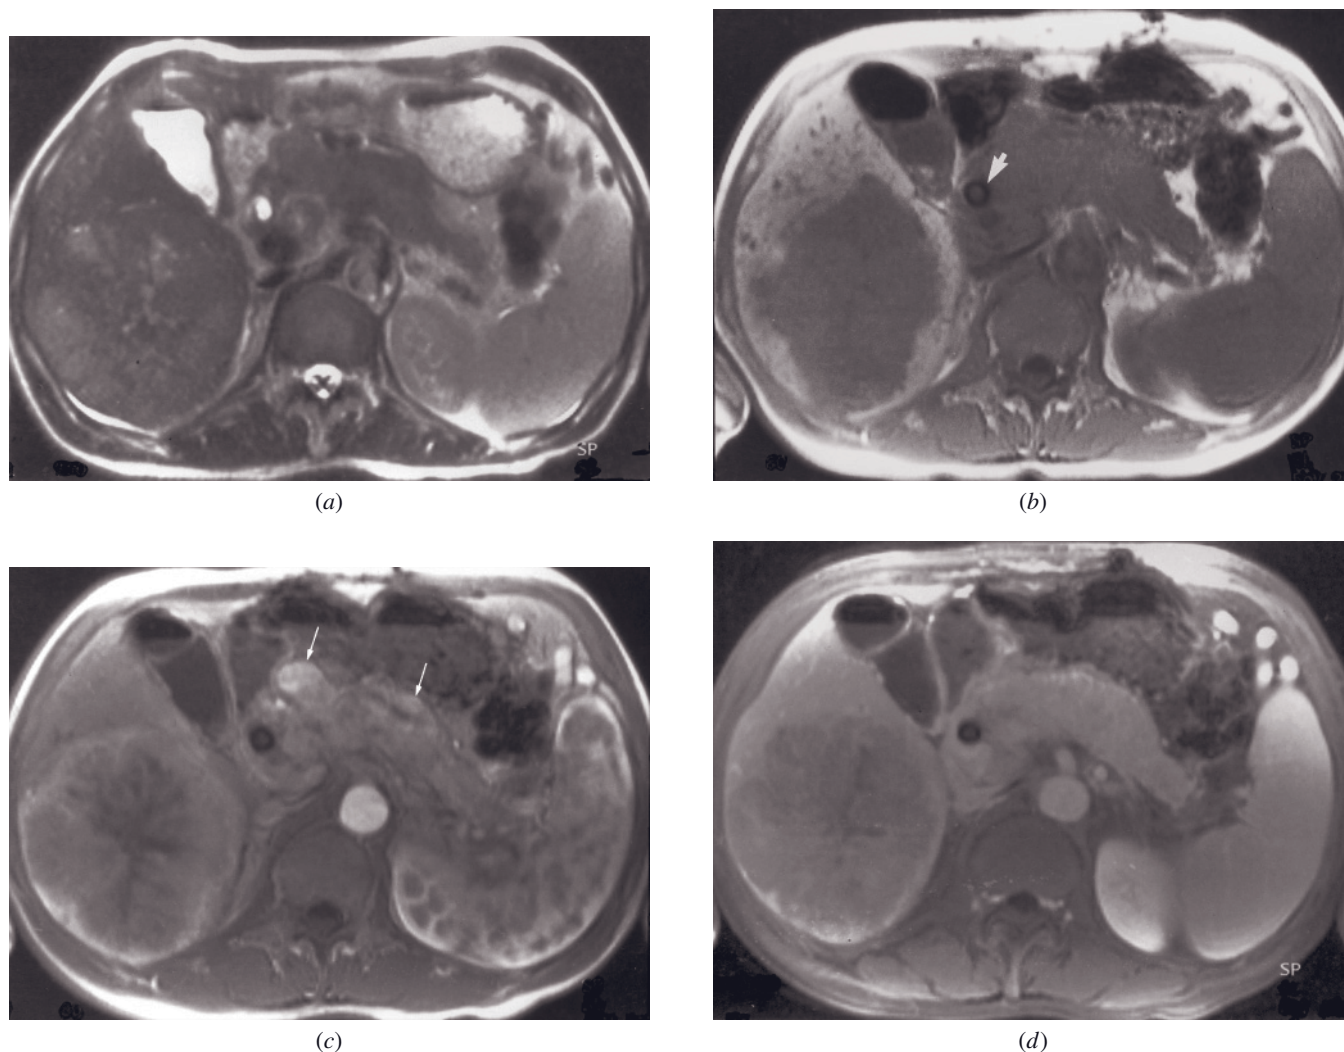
Carcinoid tumor with liver metastases. T2-weighted echo-train spin-echo (a), T1-weighted SGE (b), immediate postgadolinium T1-weighted SGE (c), and 90-s postgadolinium fat-suppressed SGE (d) images in a patient with a carcinoid tumor with diffuse involvement of the pancreas and hypervascular liver metastasis. The pancreas is diffusely enlarged with irregular contour and enhances heterogeneously on the immediate postgadolinium image (arrows, c). The metastatic liver lesion shows a radial enhancement on gadolinium-enhanced images (c, d). Note a biliary stent in the CBD (arrow, b).
